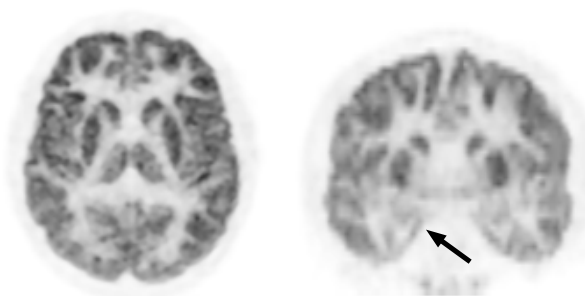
Adolescent male (early teens), epilepsy workup. BresTome FDG-PET axial (left) and coronal (right) images. Coronal image clearly depicts bilateral hippocampi and parahippocampal gyri (→). No epileptic focus was detected.
